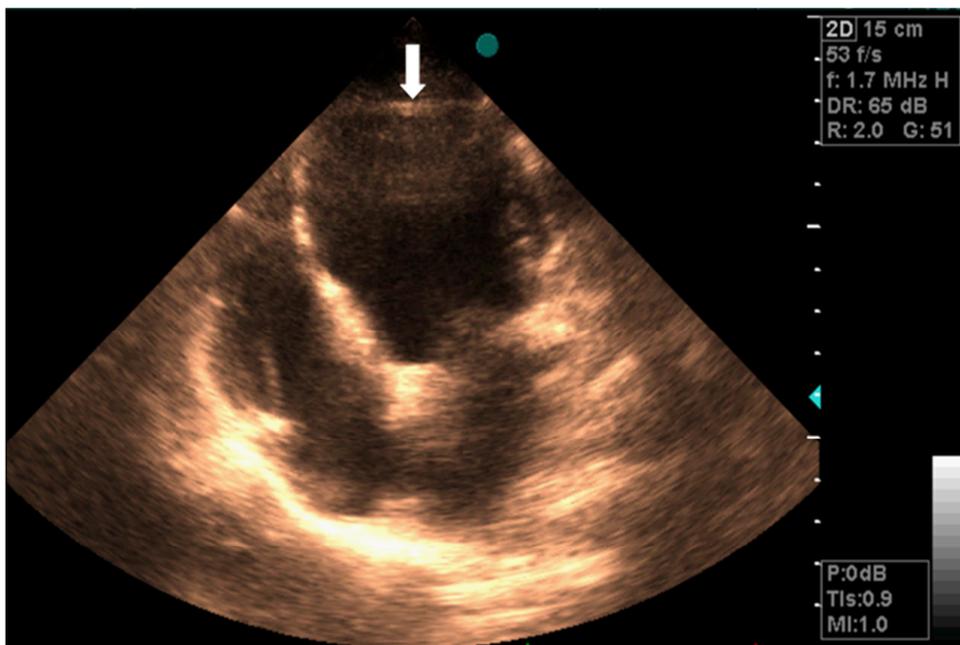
Four-chamber view in a transthoracic echocardiogram showing enlargement of the left ventricle (LV) (The LV apical structure was unclear in this view)
